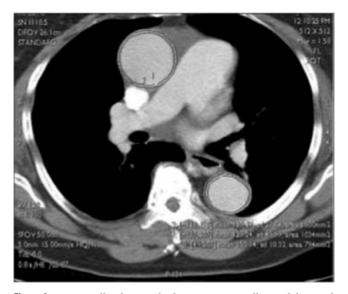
Aortic wall volume calculation. Aortic walls are delineated with a ROI on axial thoracic CT image. Inner ROIs were drawn around the aortic lumen. Outer ROIs were placed on the outer contour of the aortic wall. Net cross-sectional area values were calculated by subtracting the inner from the outer areas. Aortic wall volumes were then calculated by multiplication of area values by slice thickness. (Reprinted with permission.⁶²)
